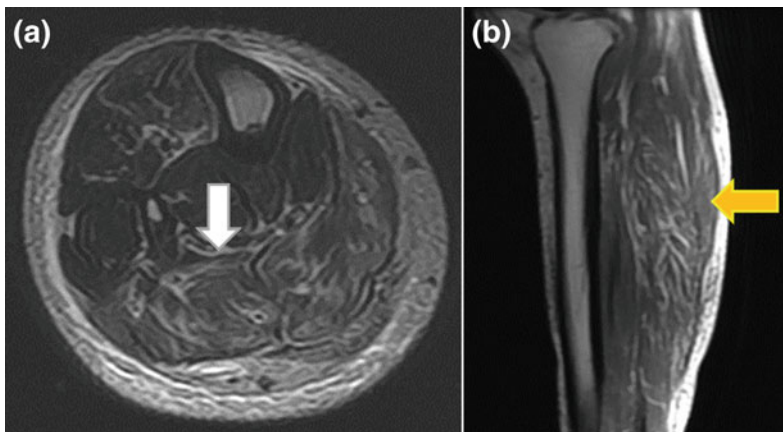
Polymyositis. An autoimmune pathological process identifiable on MRI for a fatty infiltration around muscles, as well demonstrated on these T1-w (*white arrow*) and T2-w (*yellow arrow*)
